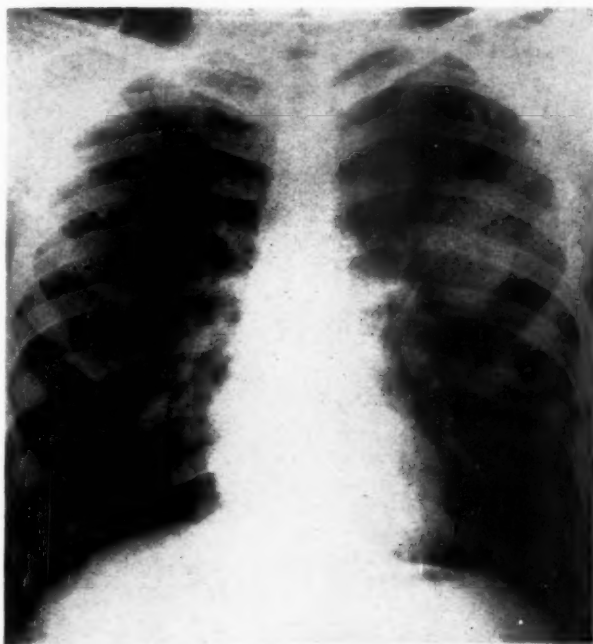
Plain roentgenogram of chest (anteroposterior view), showing oval shadow of arteriovenous aneurysm in left upper lobe.
